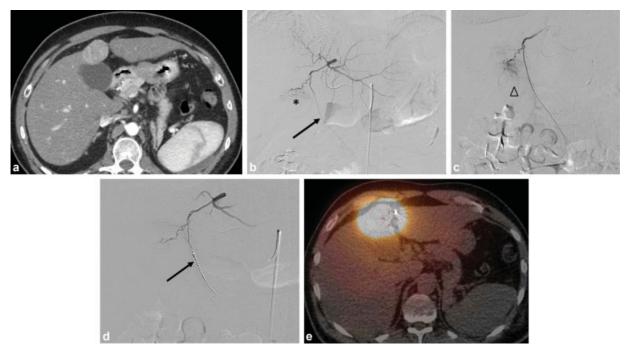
Coil embolization of a falciform artery. A 64-year-old man with hepatitis C virus cirrhosis and CT presented with a 3-cm subcapsular hepatocellular carcinoma (HCC) abutting the gallbladder (a). With plans for Y-90 radiation segmentectomy as a bridge to liver transplant, he underwent mapping angiography. Left hepatic arteriography shows tumor vascularity (asterisk) partially supplied by the falciform artery (arrow) (b). Selective arteriography before (c) and after (d) coil embolization (black arrow) of the falciform artery. (Arrowhead = tumor vascularity). Bremsstrahlung SPECT/CT shows expected focal deposition of Y-90 microspheres in the HCC and no nontarget Y-90 deposition. The patient subsequently underwent liver transplant.
